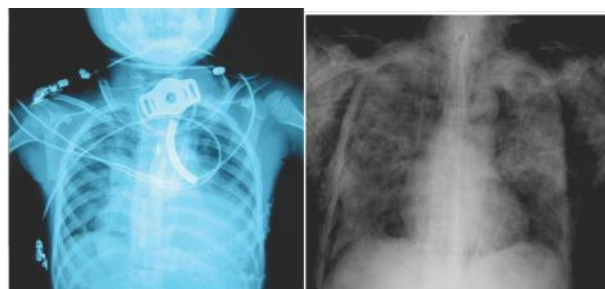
A. fractured outer tracheostomy tube dislodged into the left tracheobronchial tree with associated atelectasis and pleural effusion of the left lower zones. B. Frontal chest radiograph shows complications of tracheostomy: pneumothorax, pneumomediastinum, and surgical emphysema.
